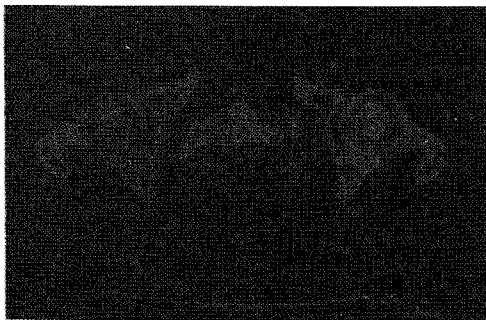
2003. 3. 27. CT in pelvis
